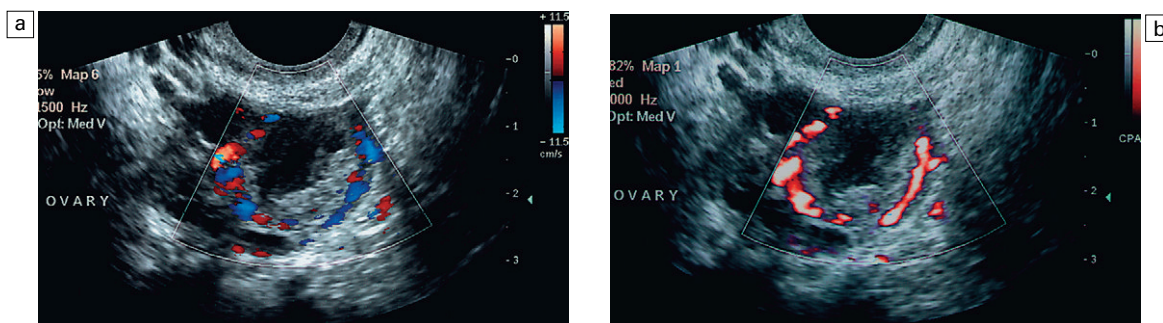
(a) Colour flow Doppler of circumferential flow in corpus luteum. (b) Power Doppler of the corpus luteum.
